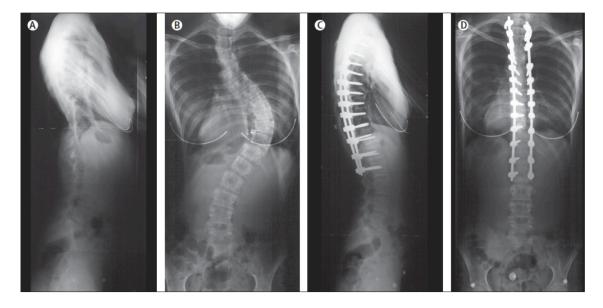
⁵⁷ Radiographs of progressive right thoracic adolescent idiopathic scoliosis before and after rod and pedicle screw fixation. A) Preoperative standing lateral view, B) preoperative standing posterior-anterior view, C) postoperative standing lateral view, and D) postoperative standing posterior- anterior view.
